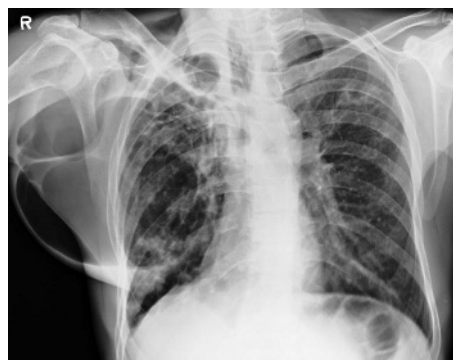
Chest radiograph showing bilateral airspace consolidation with multiloculated radiolucent area in the right lung field and an extrathoracic extension containing a fluid level.
